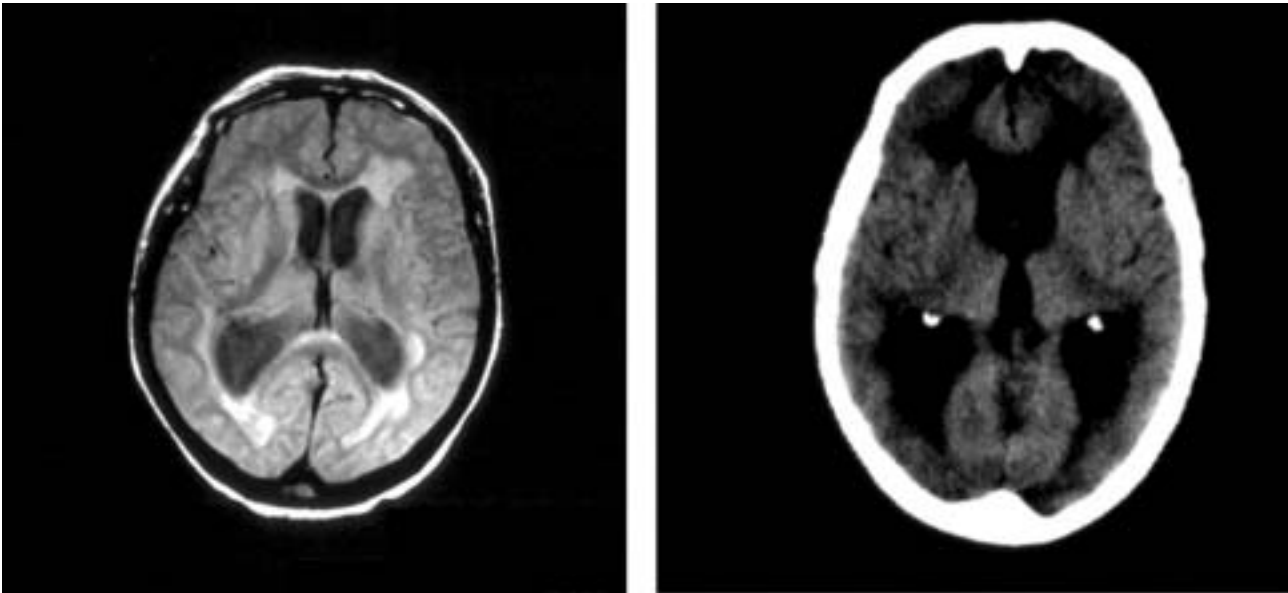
A computed tomographic scan (left) and magnetic resonance imaging (right) without contrast injection reveal severe isolated quadriventricular hydrocephalus 32 months after renal transplantation.
